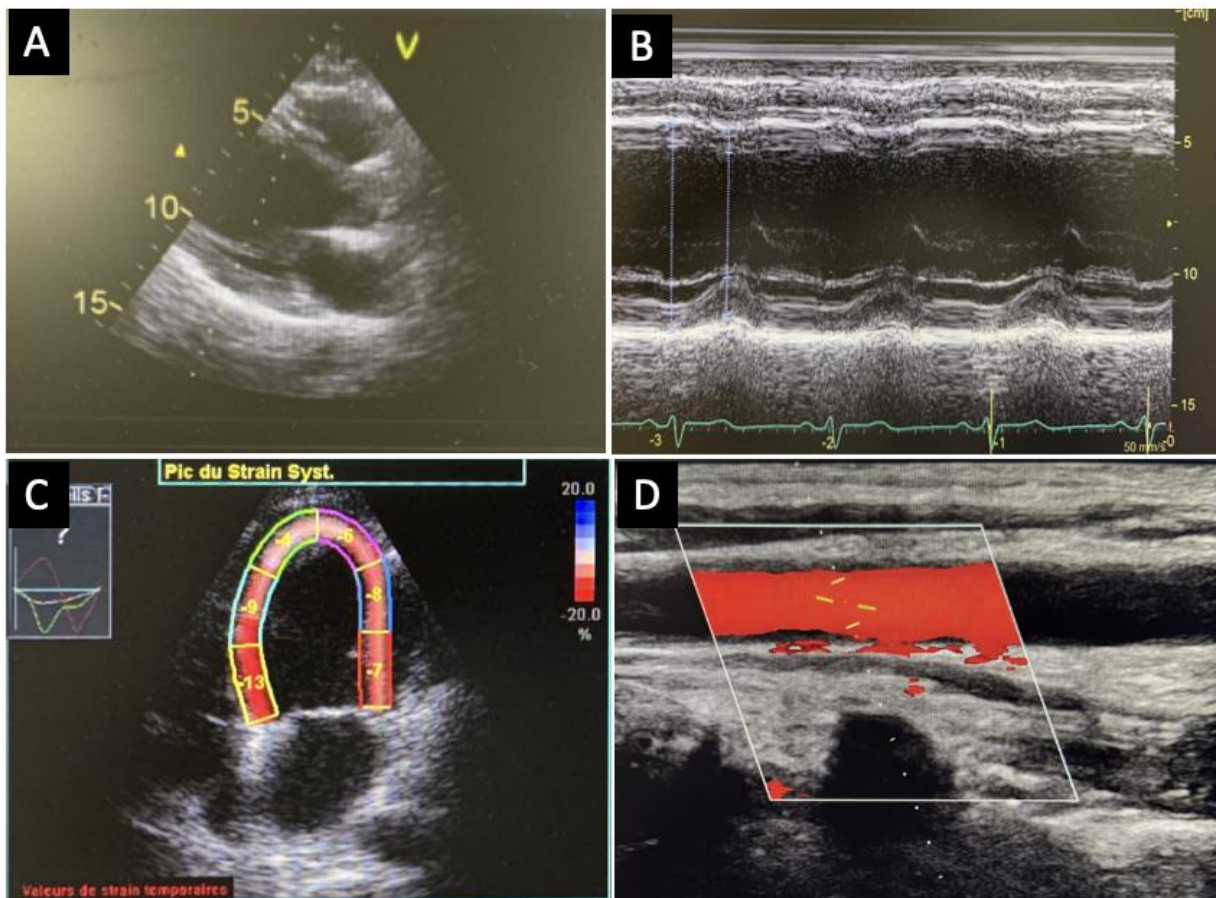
A, B, C images: transthoracic echocardiography images demonstrating a dilated left ventricle with dysfunction. D: Arterial echodoppler of the left carotid artery showing slight atheromatous deposits
